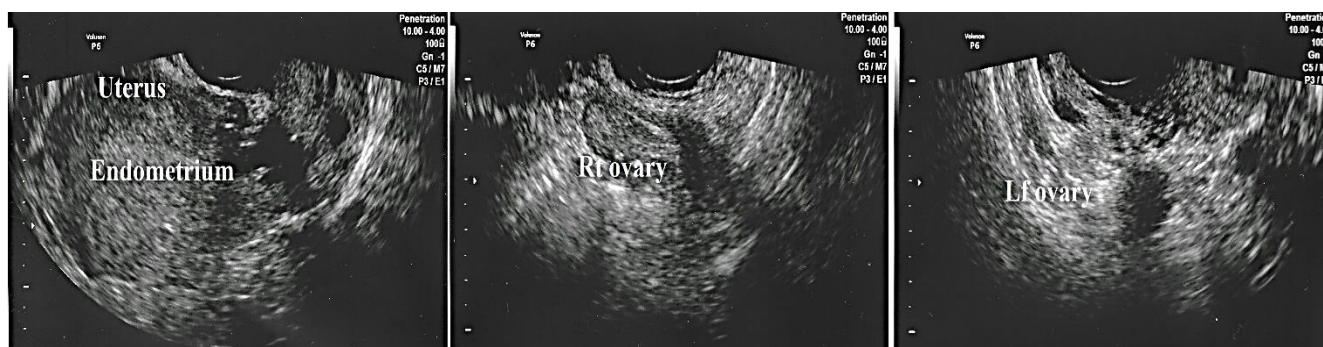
A regular ultrasound examination performed at the scheduled follow-up after pregnancy
